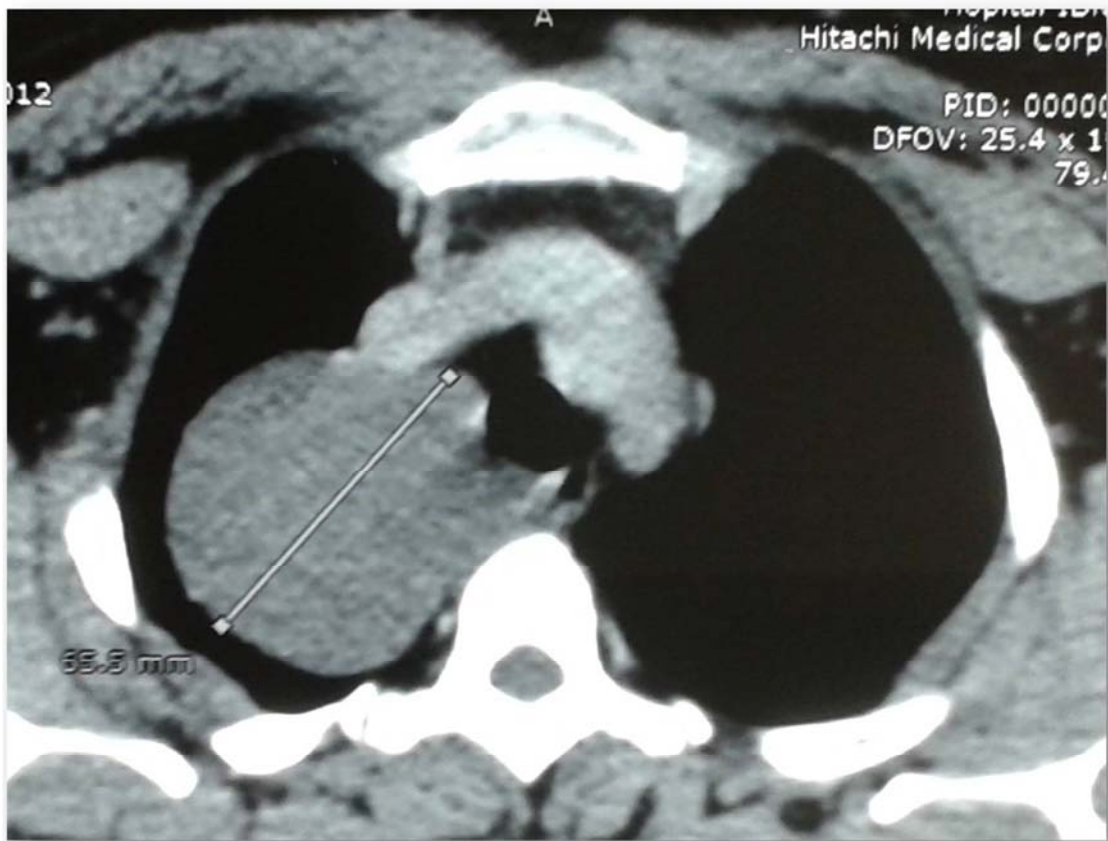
CT scan showing a right paratracheal cystic mass.
